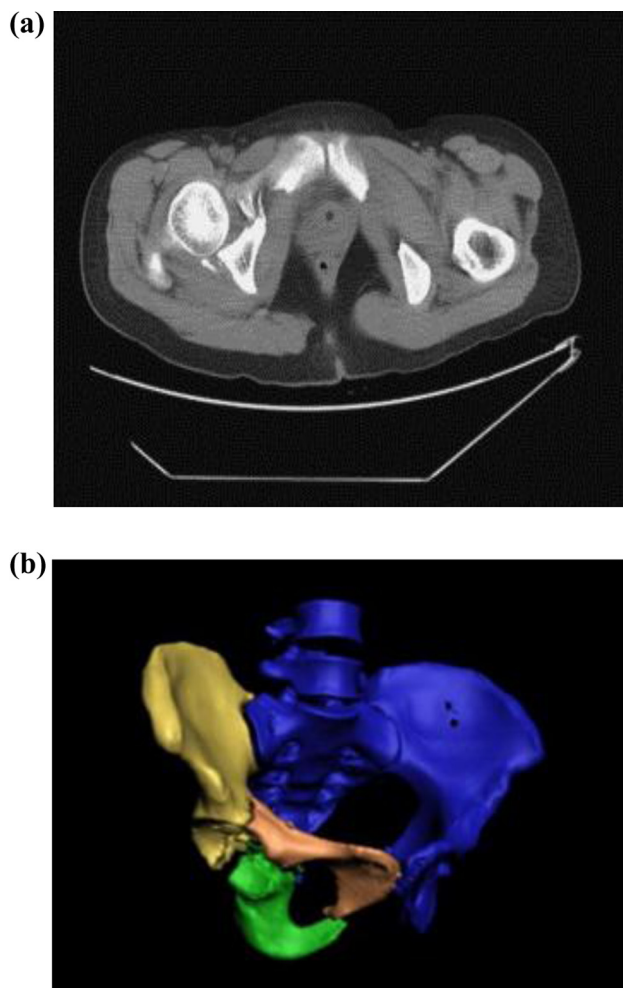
a Axial CT image of acetabular fracture. Injury. 2011 Oct; 42(10):1121–4, b Three dimensional reconstruction of the displaced T-shaped acetabular fracture. Reprinted from Ref. 21 with permission from Elsevier.
